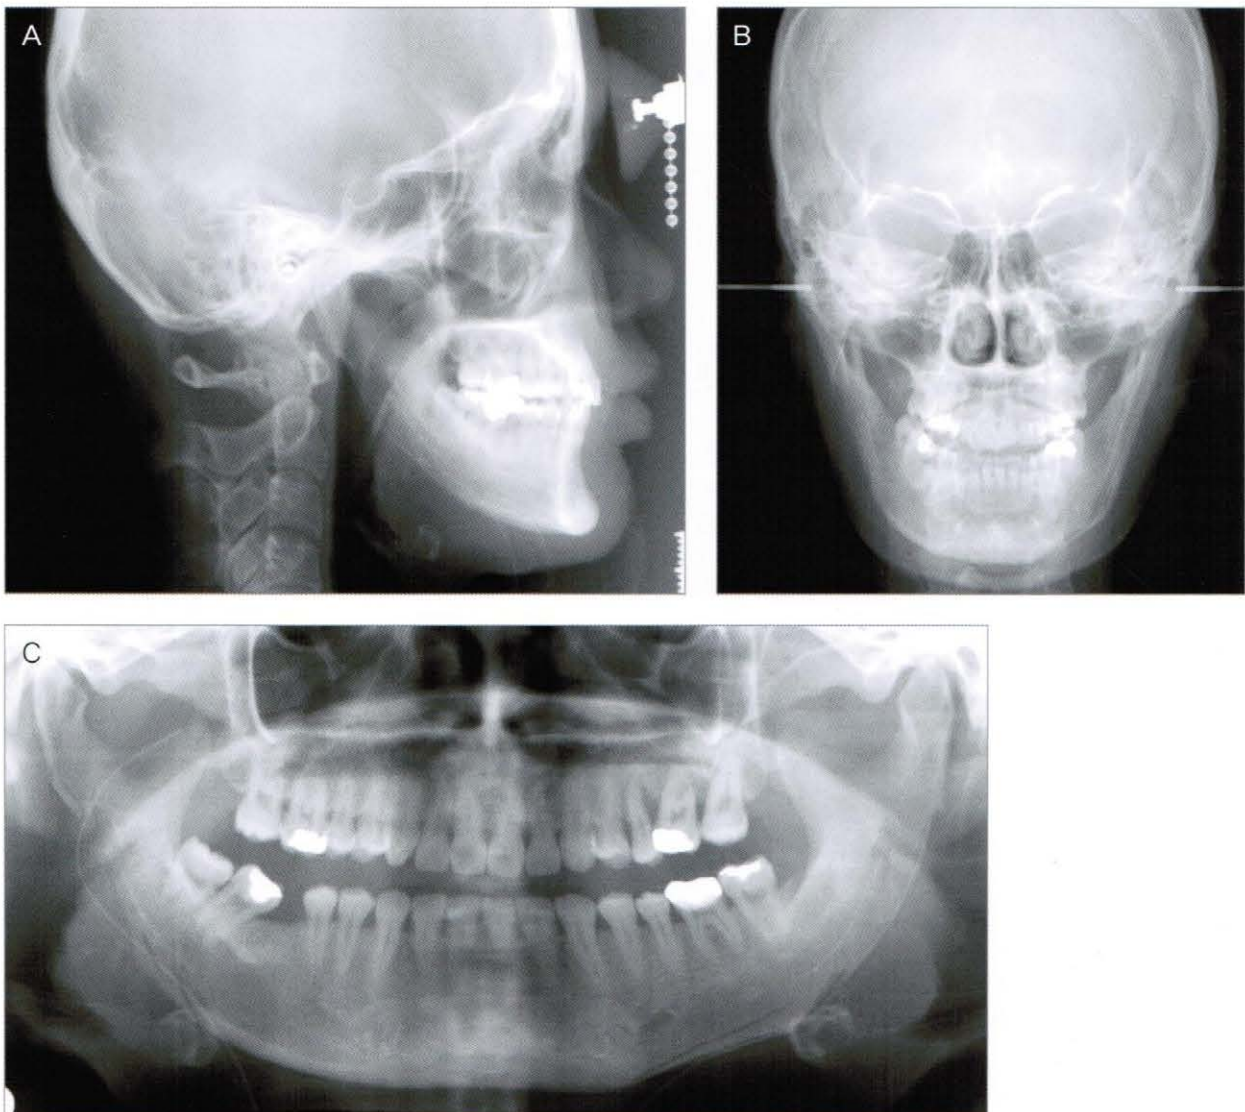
Cephalometric radiograph (A), postero-anterior radiograph (B) and panoramic radiograph (C) taken after surgery (2005, 10,7)
